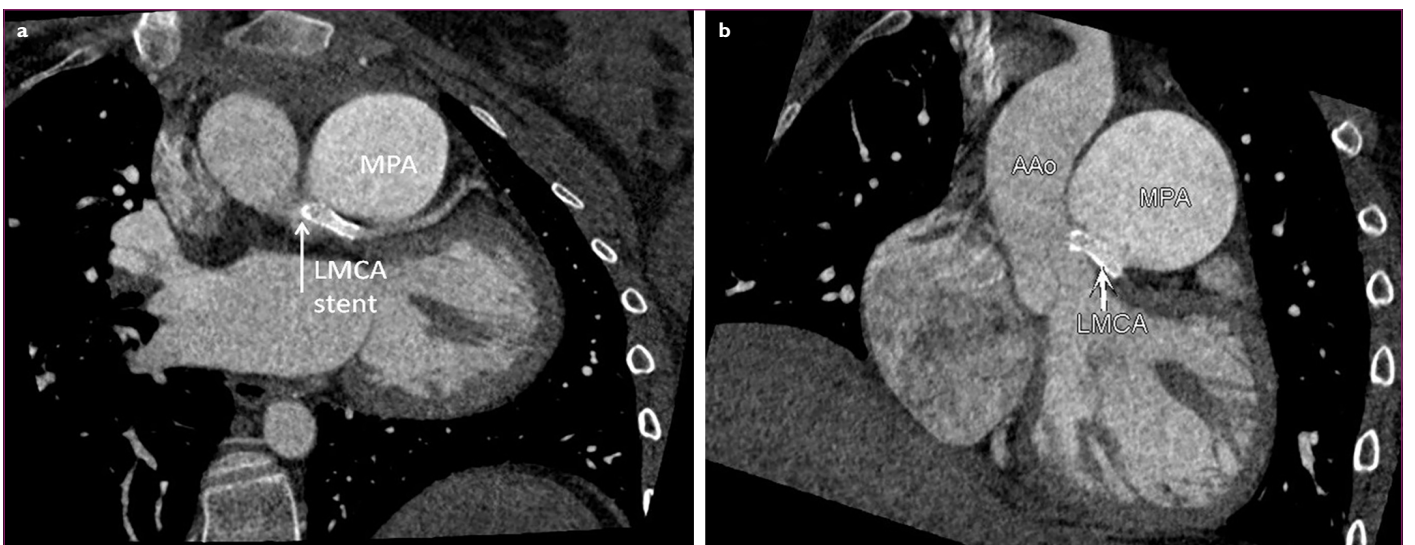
The LMCA stent was visualized as the patent on coronary CT angiography.
